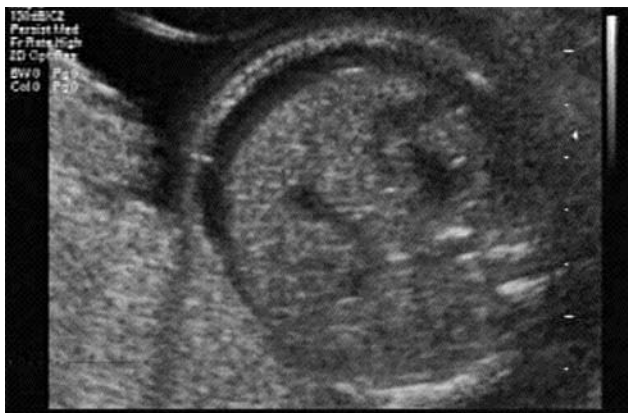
Ultrasound appearance of a fetus with hydrops fetalis. Note the presence of fluid in the fetal abdomen.
